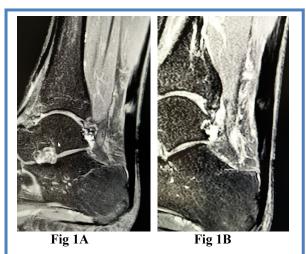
Case A (MRI, sagittal plane): Achilles Tendon Lesion before (1A) and 2 months after (1B) the regenerative intervention (the images are published with the patient's consent).
